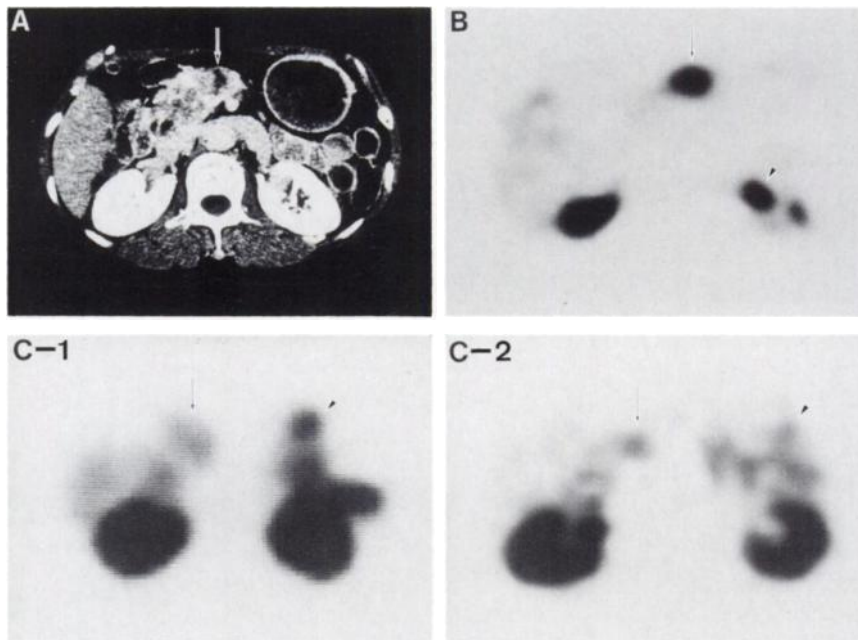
(A) CE-CT shows irregular-margined low density mass (arrow) in the body of the pancreas (Patient 8). (B) FDG-PET shows significantly hot accumulation in the tumor (arrow) with a T/N ratio of 3.45. FDG accumulation in the left ureter is also observed centrally (arrow head). (C) Comparison of ^{201}Tl -SPECT images using a single-head camera system (C-1) and a three-head camera system (C-2). The image quality is superior in the latter, however, the T/N ratio of the activity has not improved. Significantly high tracer accumulation in the stomach and intestine is observed on both SPECT images (arrow head).
